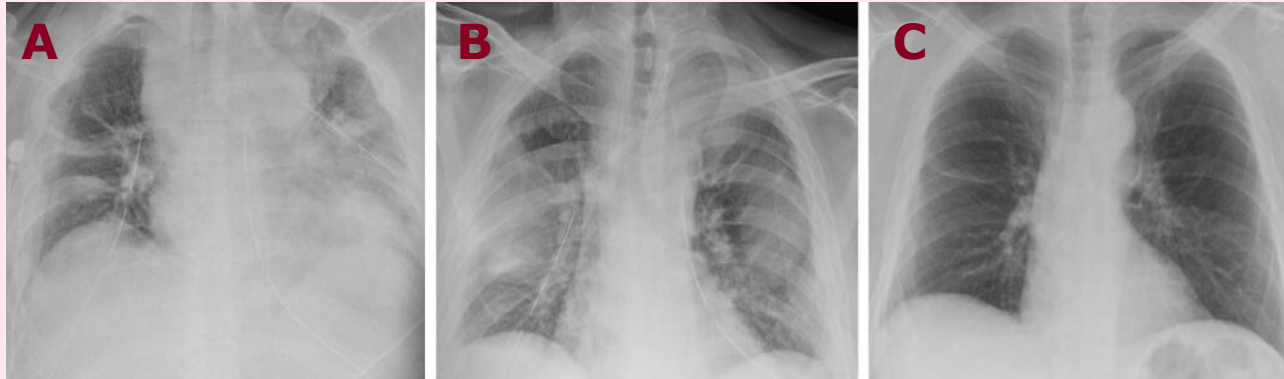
Chest radiography - first postoperative day (A); tenth postoperative day(B); three weeks after operation(C)
